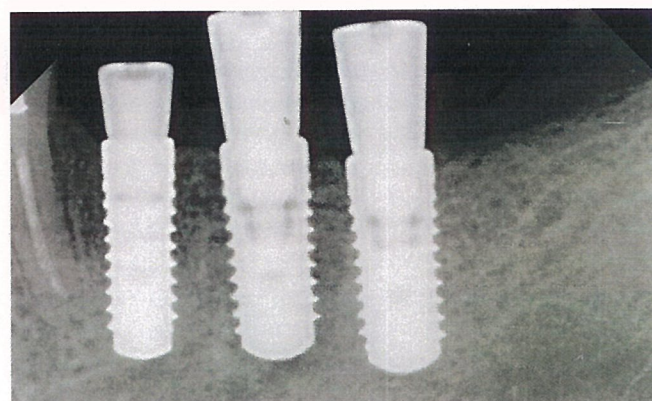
Control X-ray of the implant in place.
